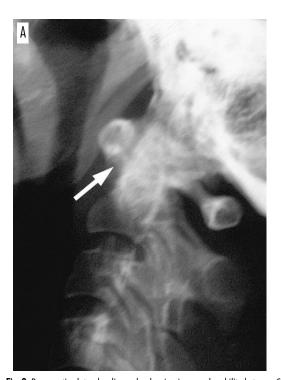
Preoperative lateral radiographs showing increased mobility between C1 and C2. Anterior atlantodental interval (arrow) measured in extension (A) was 4 mm, whereas in flexion (B) it was 8 mm
